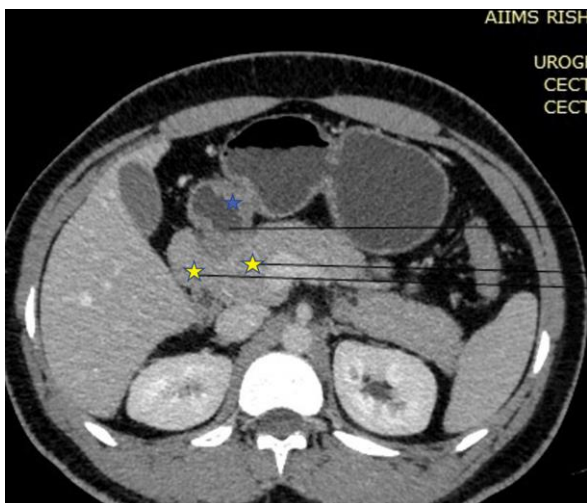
32 years old male. Axial section of abdomen on contrast-enhanced computed tomography (CECT), showing second part of duodenum (marked by blue star), being incompletely encircled by pancreatic tissue (marked by yellow stars). A typical crocodile jaw configuration of the pancreatic tissue is seen around the second part of duodenum
